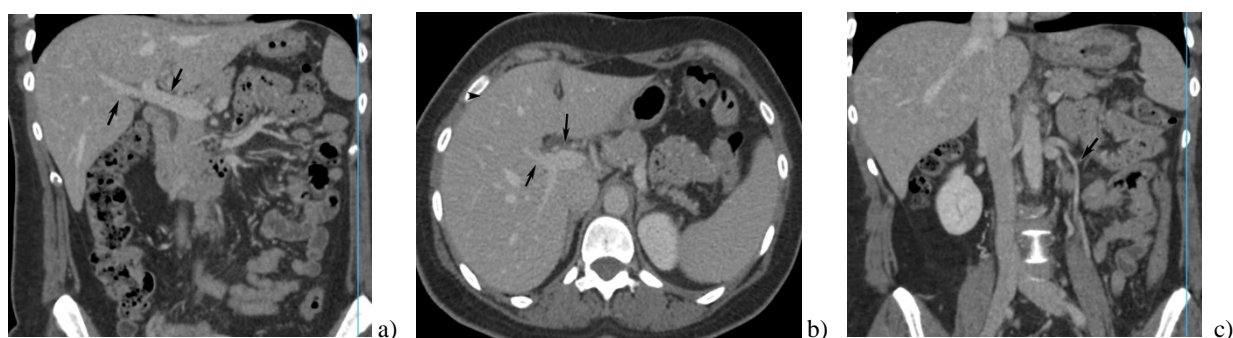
Multislice computed tomography angiography of the abdomen, control scan, month after discharge from the hospital: a) Resolved PVT-coronal plane (black arrows); b) Resolved PVT-axial plane (black arrows); c) Resolved IMVT-coronal plane (black arrows).
